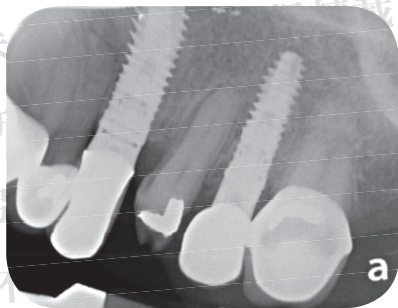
Periapical radiograph of the relationship between tooth #24 and the tooth #25 dental implant on September 27, 2016.
